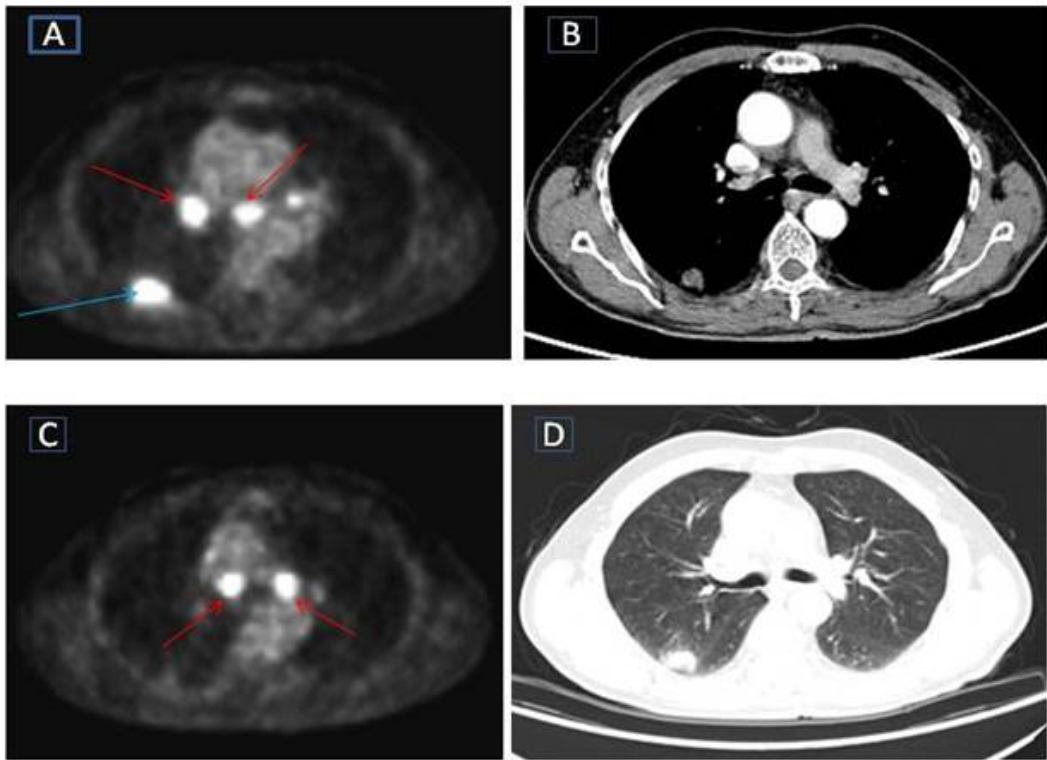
A 68-year-old man with pulmonary adenocarcinoma presenting for staging evaluation. He had 60 years of exposure to biomass smoke history. Axial positron emission tomography/computed tomography (PET/CT) (A) shows a right upper lobe 2.5 cm mass, maximum standardized uptake values (SUVmax): 8.23 (blue arrow); right hilar adenopathy SUVmax: 7.04; and subcarinal lymph node SUVmax: 6.04 (red arrow). (C) Axial PET/CT shows bilateral paratracheal lymph adenopathy, SUVmax: 6.86 (right) and 9.88 (left) (red arrow). (B and D) CT with mediastinal and lung windows shows a right upper lobe mass. With endobronchial ultrasound transbronchial needle aspiration, all lymph nodes were found to be anthracotic. The patient underwent mediastinoscopy and lymph nodes were anthracotic. Right upper lobectomy and lymph node dissection were performed and postoperative pathology of lymph nodes confirmed anthracosis.
